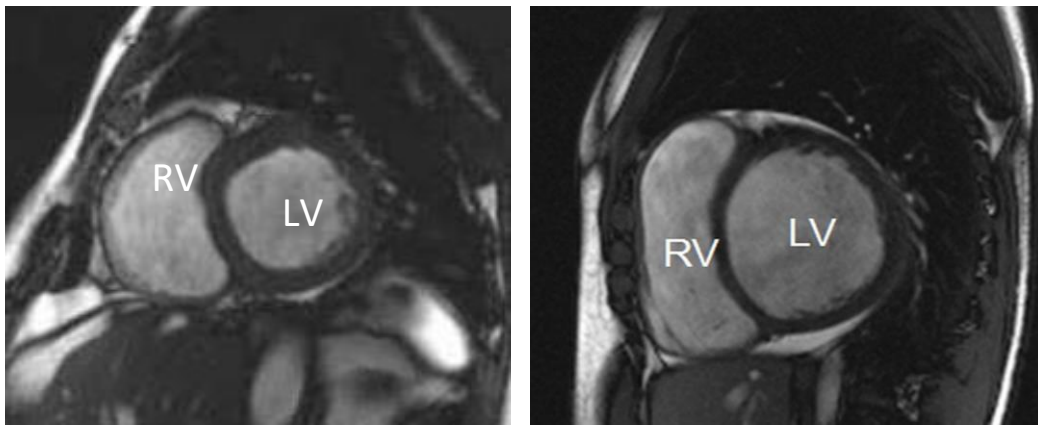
Representative short axis MRI of a healthy patient (left) and a patient with DCM (right). The DCM patient has a dilated LV and a thinner LV wall in comparison to the healthy patient, who has a non-dilated LV and an LV wall with normal thickness. Adapted from [21][22].
